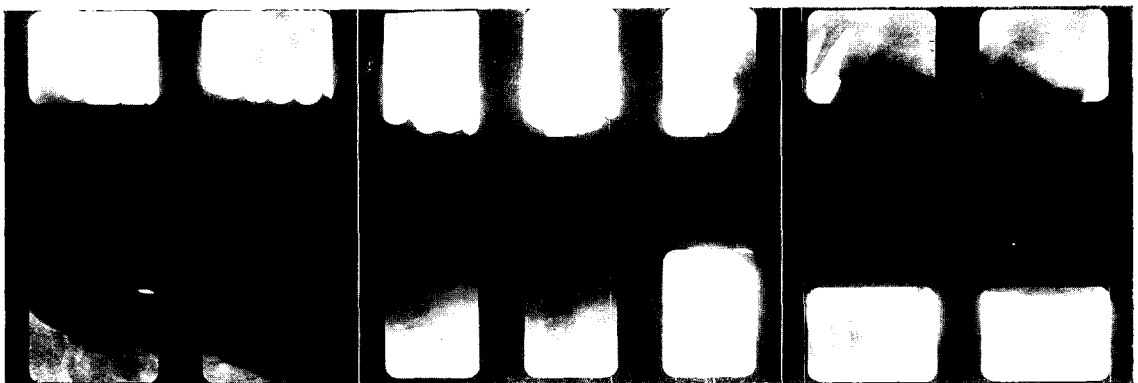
Periapical radiographs demonstrating wispy trabeculation and loss of alveolar lamina dura.
